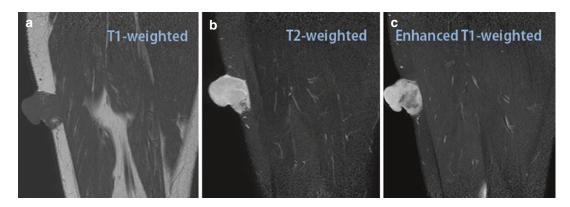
(a–c) Parasagittal T1- (a), T2- (b), and postcontrast fat-saturated T1-weighted MR images of the thigh. Multinodular lesion in the subcutis with protrusion
